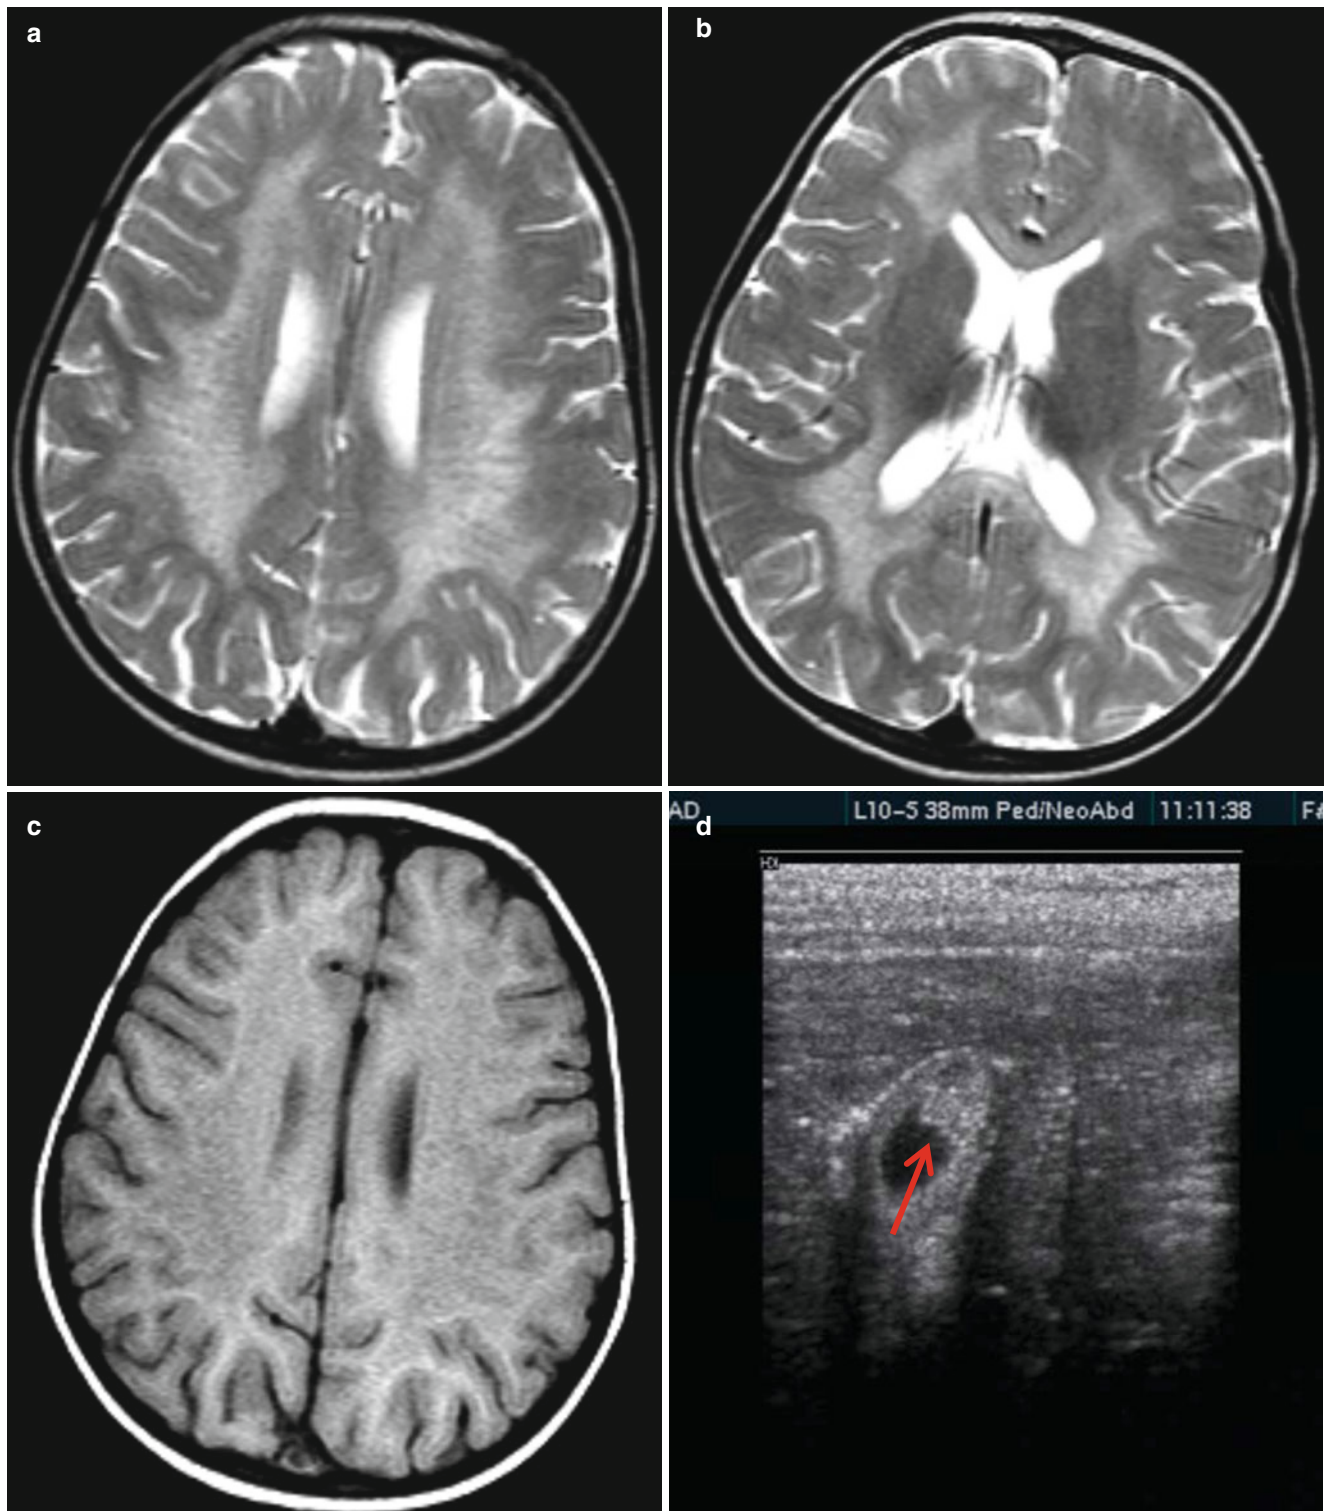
Metachromatic leukodystrophy in a 2-year-old girl. (a, b) T2-weighted image shows bilateral symmetric, confluent high signals of the deep and periventricular white matter extending to the corpus callosum. Fine linear low signals within the high signals perpendicular
